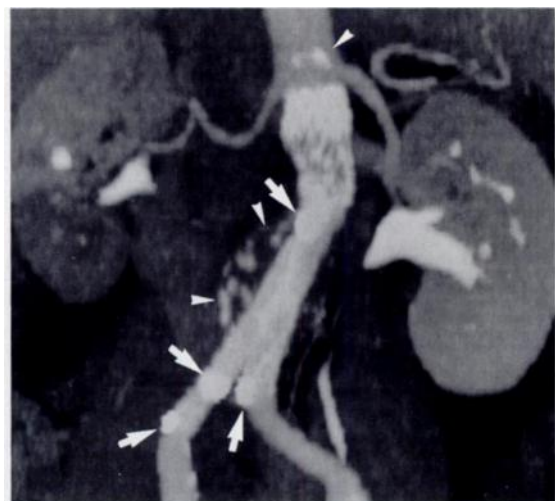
MIP image demonstrates an abdominal aortic aneurysm after treatment with an aortic stent prosthesis. The mural calcification outlines the thrombosed portion of the aneurysm. Note the difference in CT numbers of the aortic lumen, calcifications (arrowheads), nitinol stent, and platinum markers (arrows). Thrombus and wall calcifications can be directly visualized in large aneurysms if a narrow VOI (anteroposterior width less than the diameter of the aneurysm) is used. In this case, an accessory renal artery on the right side had been sacrificed. The resulting hypoperfusion of the lower pole of the kidney is seen.
